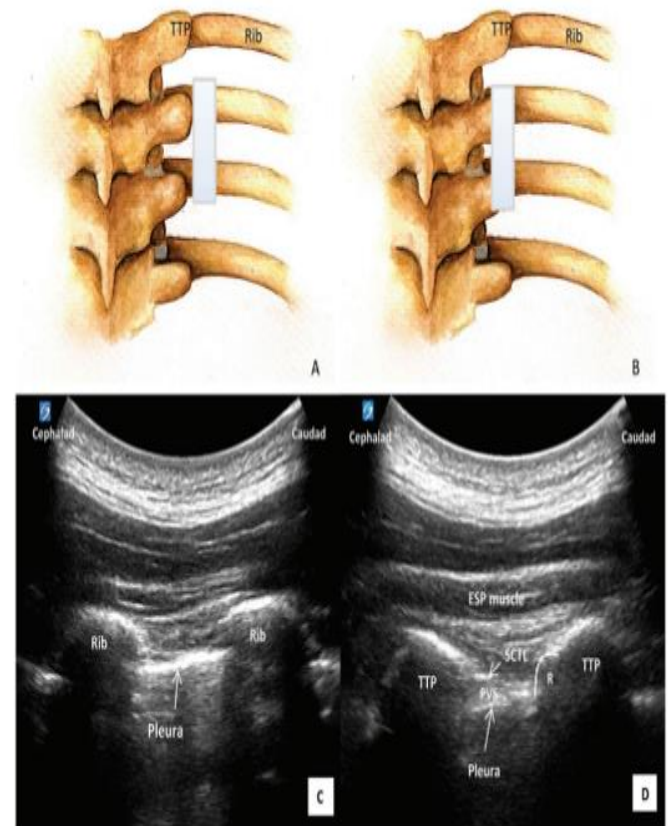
Posterior view of thoracic spines and ribs with ultrasound probe positions (white bar, A and B) and ultrasonographic visualization to identify the ribs and TP in the sagittal plane for the CTF block (C and D). (A, C) The ultrasound transducer was placed between 2 ribs (fourth to fifth), the ribs appear as convex structures, and the pleural line is the horizontal hyperechoic line between the ribs. (B, D) The ultrasound transducer was placed between the 2 TPs (fourth to fifth). The TP is visualized as a square structure, and the fifth rib appears as a step-down of the hyperechoic convex line superior to the fifth TP. The paravertebral space is located between the hyperechoic lines of the superior costotransverse ligament and the pleura. PVS, paravertebral space⁽³³⁾.
